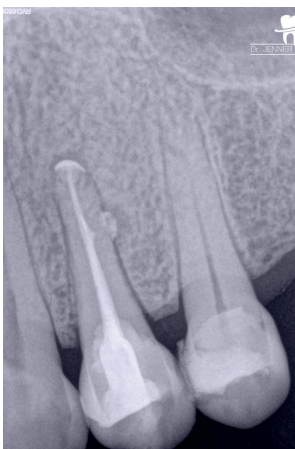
Final x-ray taken at an orthoradial angle; cement puffs can be observed in the periapical regions.
